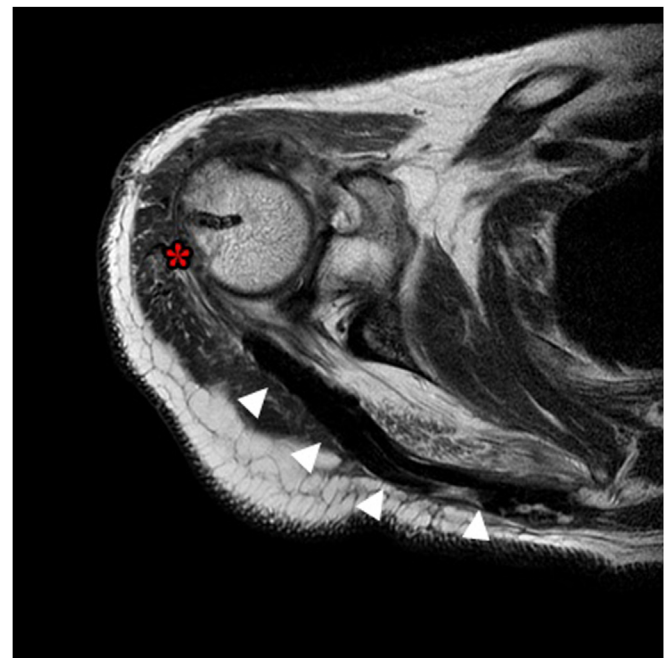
Retear after initial lower trapezius tendon transfer. Magnetic resonance image (MRI) scan of right shoulder of shows retear [red asterisk] of lower trapezius tendon transfer [white arrow head] at greater tuberosity in oblique axial view of MRI scan.
